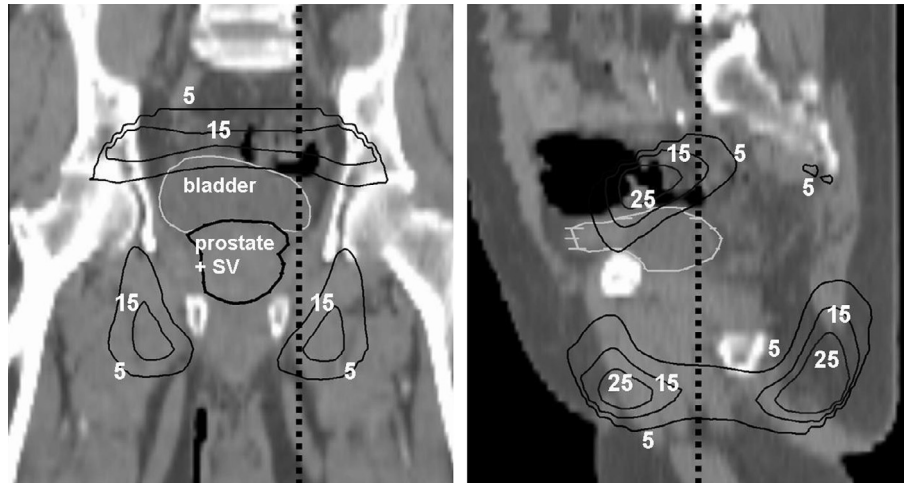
Dose differences between rectangular and conformal arm (iso dose lines). Coronal (left) plus sagittal (right) CT view of a sample patient. The dotted line indicates the position of the other CT view.
